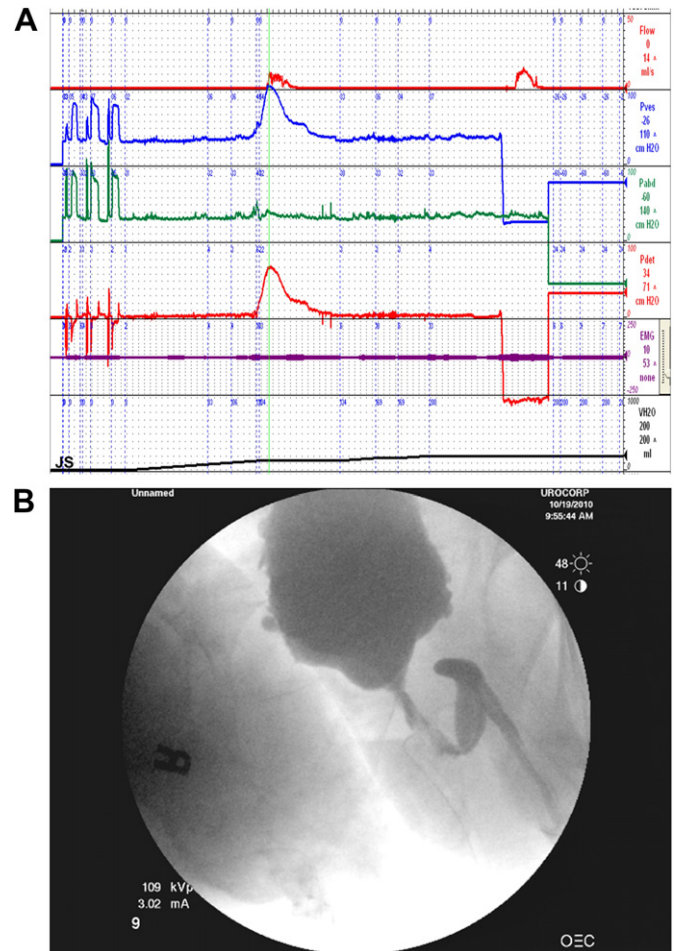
Overestimation of bladder outlet obstruction (BOO). A 65-year-old man with severe overactive bladder (OAB) symptoms. He underwent KTP laser ablation of the prostate and transurethral resection of the prostate (TURP), but his symptoms persisted. Cystoscopy showed considerable trilobar enlargement and moderate intra-prostatic protrusion with some signs of prior resection/ablation. There were also some inflammatory-looking polypoid lesions in the prostatic urethra. The bladder mucosa had multiple areas of flat erythema, but a biopsy showed only inflammation. A. Urodynamic tracing. $P_{\det@Q_{\max}}$ = 105 cmH₂O; Q_{\max} = 10 mL/s; BOOI index (BOOI) = 105 - 20 = 80; Schaefer grade 5 obstruction. Unintubated Q = 15 mL/s (at the conclusion of the urodynamic study). B. X-ray obtained at Q_{\max} showing a wide-open proximal prostatic urethra, some narrowing of the distal prostatic and membranous urethra, and a normal distal urethra. Despite the elevated BOOI, the presence of the normal unintubated flow mitigated against a diagnosis of BOO, and a third prostate ablating surgery might not be successful.
